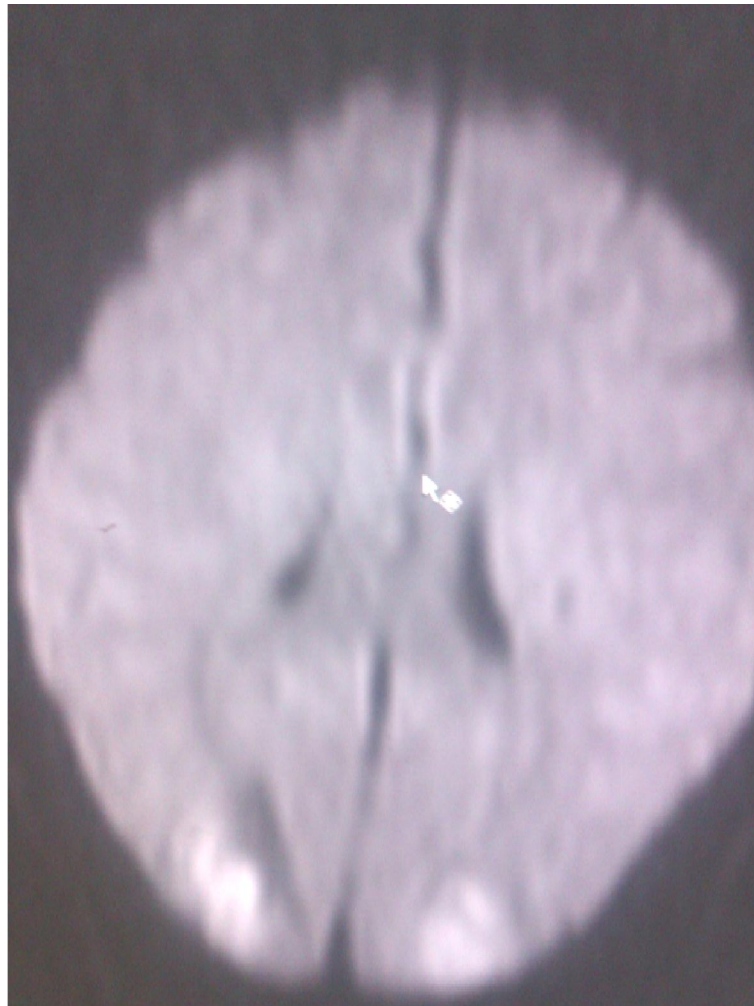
DWI Brain showing diffusion bright lesion in the bilateral occipital regions –complication of PRES – Infarct showing Diffusion Restriction
